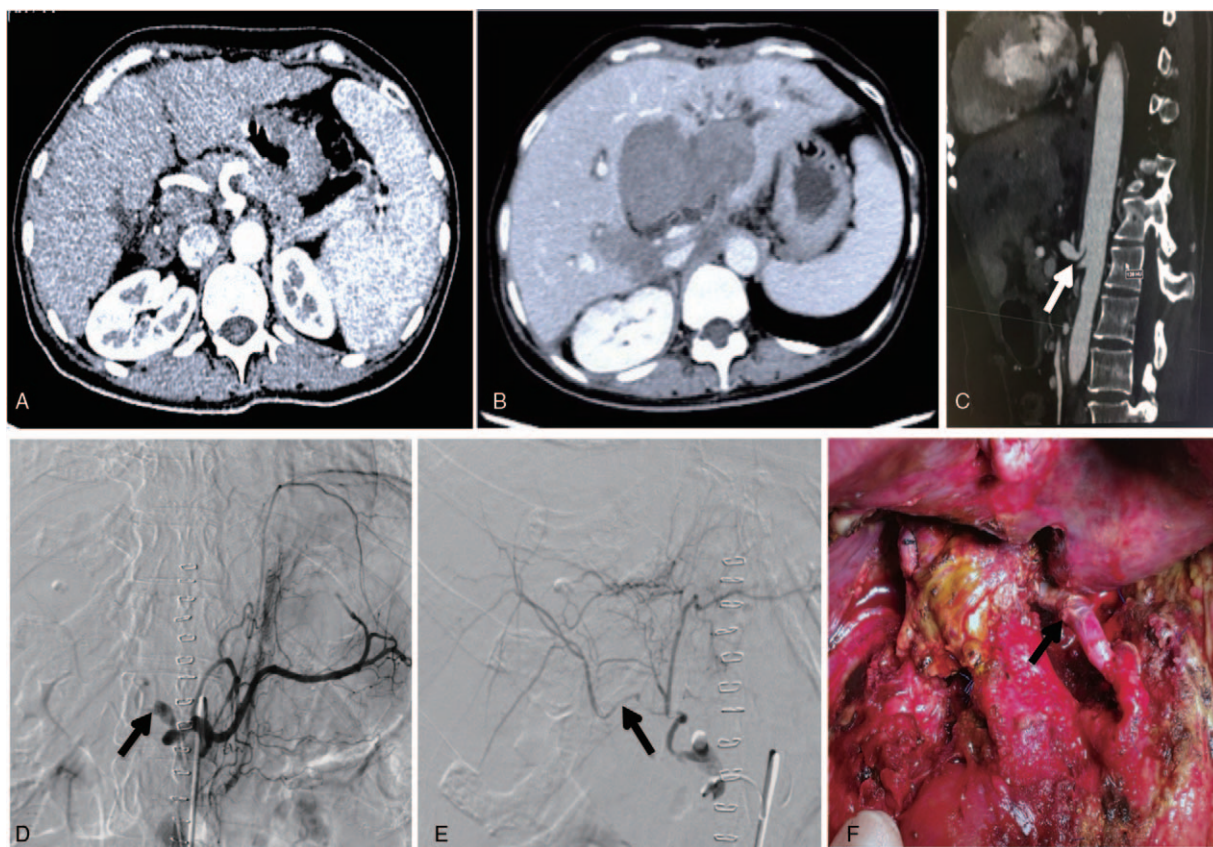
Diagnostic data for MALS and hepatic arterial thrombosis. (A) Enhanced CT before the first transplantation. (B) Enhanced CT on POD9 showing the formation of hematoma, dilatation of the intrahepatic bile duct, and the ischemic lesion. (C) Computed tomographic angiography showing stenosis of the celiac trunk (arrow) compressed by the MAL. (D) DSA in anteroposterior projection of the celiac trunk performed on POD 10 (after the exploratory laparotomy) showing thrombosis of hepatic arterial anastomosis (arrow). (E) DSA in anteroposterior projection of hepatic artery performed on POD 10 (after the exploratory laparotomy) showing decreased blood supply and thrombosis of the hepatic artery (arrow). (F) Intraoperative photograph showing hepatic arterial thrombosis (arrow) during salvage liver transplantation. DSA=digital subtraction angiography, MAL=median arcuate ligament, MALS=median arcuate ligament syndrome, POD= postoperation day
